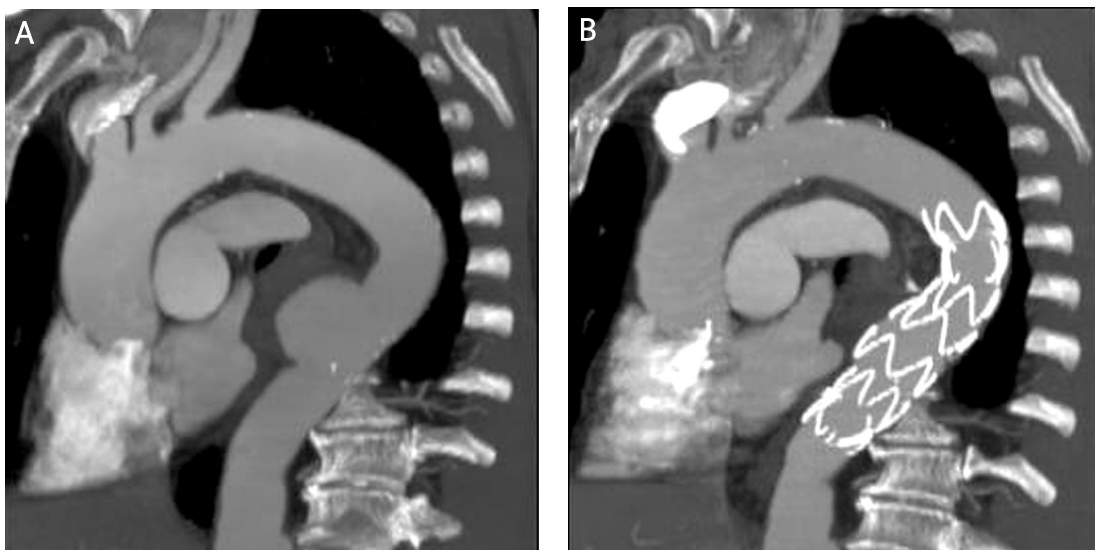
(A) CT angiogram showing a circumscribed aneurysm of the descending thoracic aorta in a middle-aged male patient selected for endografting. (B) 1-year follow-up after successful endovascular exclusion of the aneurysm by stent-graft placement demonstrates marked shrinkage of periprosthesis aneurysm and optimal wall apposition of the stent graft
